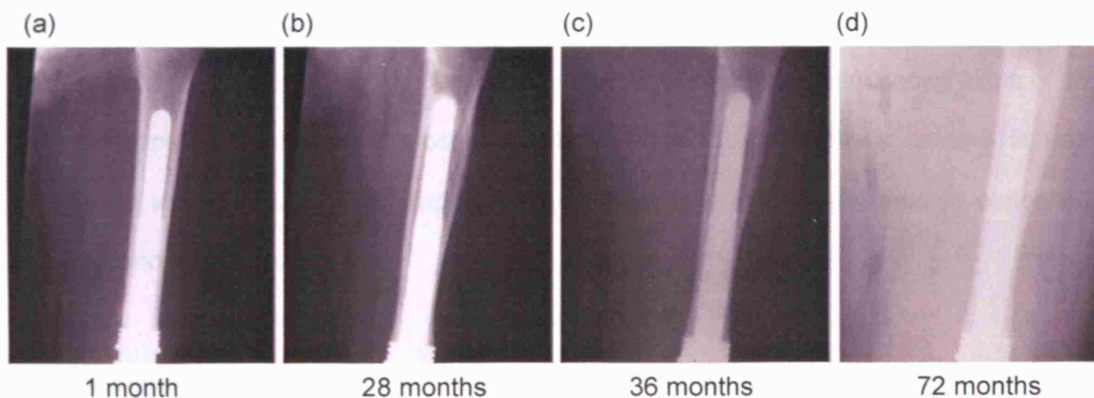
Radiographs of remodelling around distal femur prosthesis at (a) one month after implantation (b) 28 months, (c) 36 months and (d) 72 months. Courtesy of Professor G. Blunn, Centre for Biomedical Engineering, University College London.
